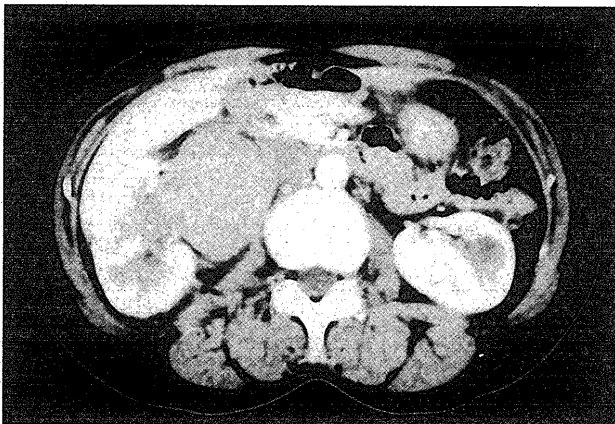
Computed tomography shows a retroperitoneal mass.
